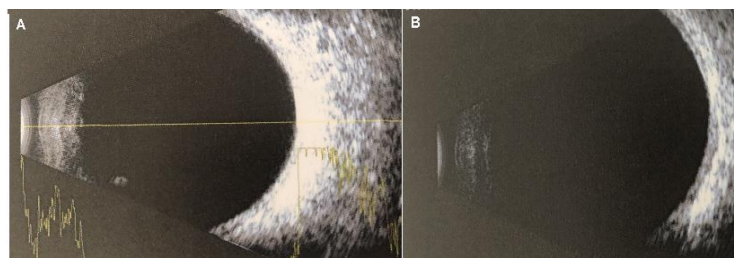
Ultrasound B-scan was within normal limits
